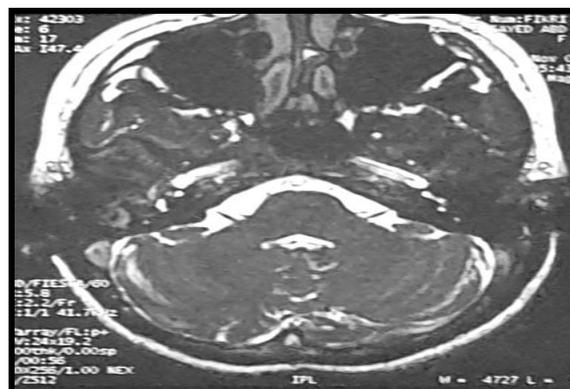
DW MRI axial view 6 months after surgery showing no recidivistic lesion.
